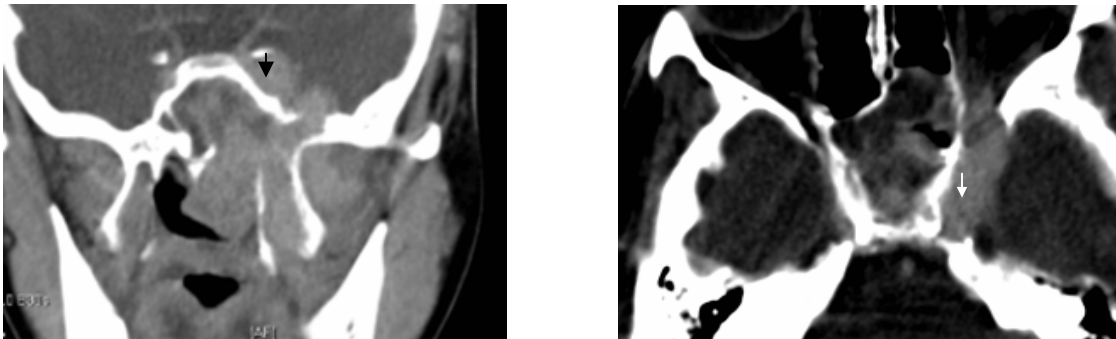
Coronal CT scan shows a mass filling left nasopharynx, sphenoid sinus, right cavernous sinus(*black arrow*).b. Axial CT scan filling left cavernous sinus(*white arrow*).
